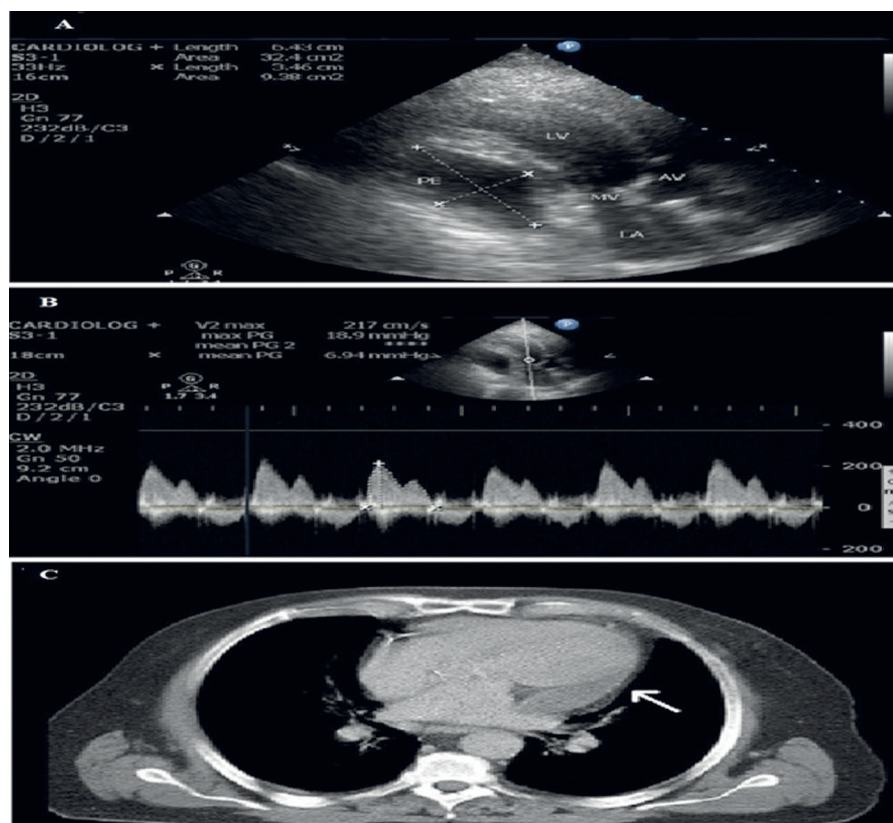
Transthoracic echocardiography (TTE) shows large pericardial effusion (A), moderate mitral valve stenosis (B), and thickened pericardium surrounding the left ventricle (C, arrow) before medical treatment.
